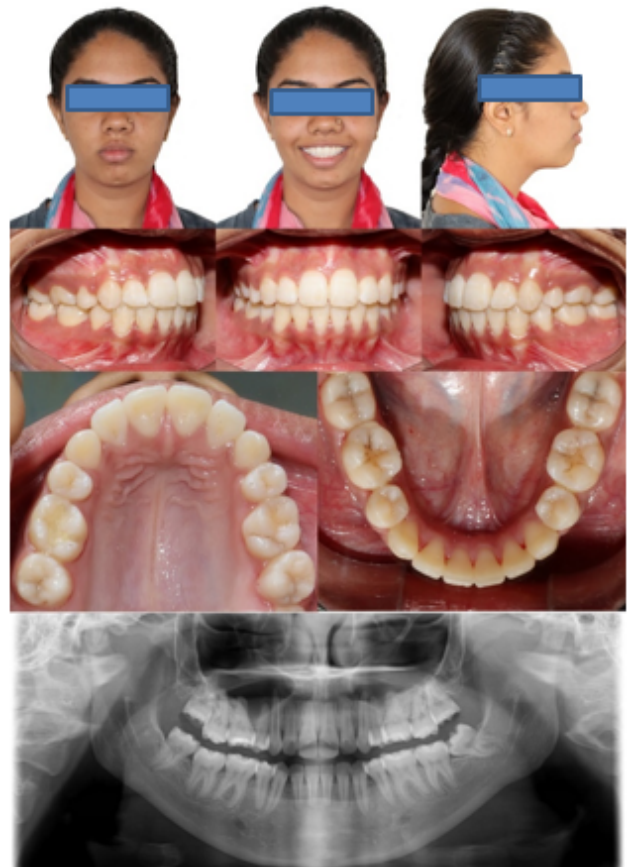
Posttreatment extraoral, Posttreatment intraoral, posttreatment Orthopantomogram.
